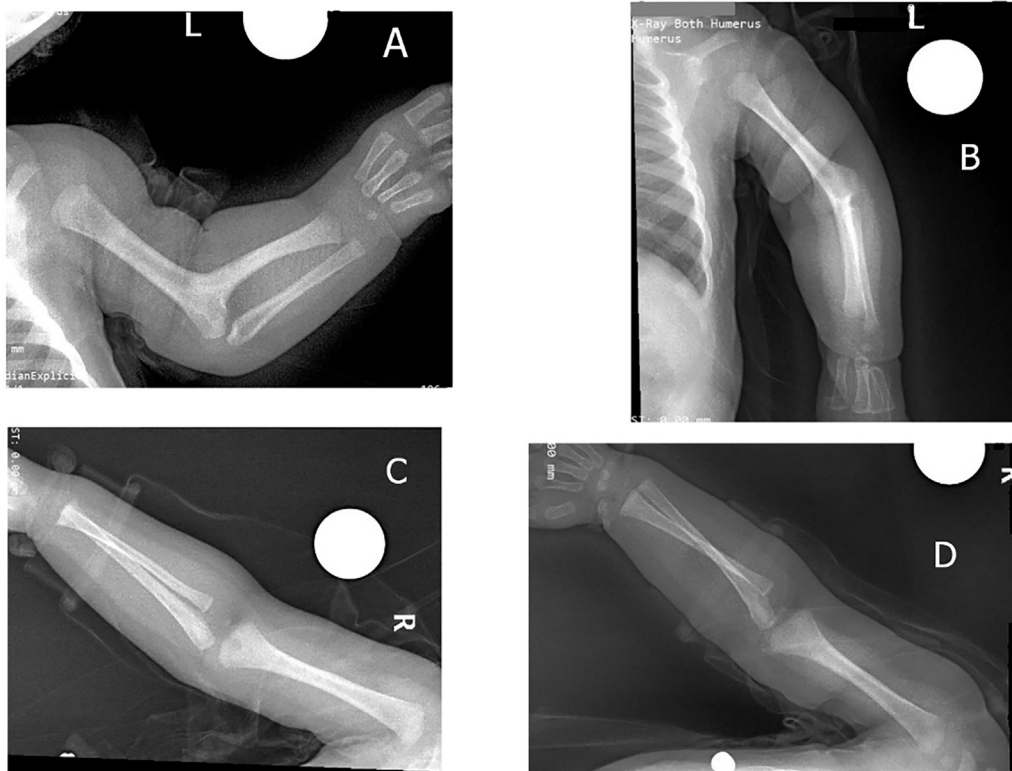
Radiographs of both upper limbs. Images A and B are of the left upper limb and show a fusion of the distal humerus and proximal radius, absence of the first metacarpal, and the first proximal phalanx. Images C and D show the normal appearance of the right upper limb.
